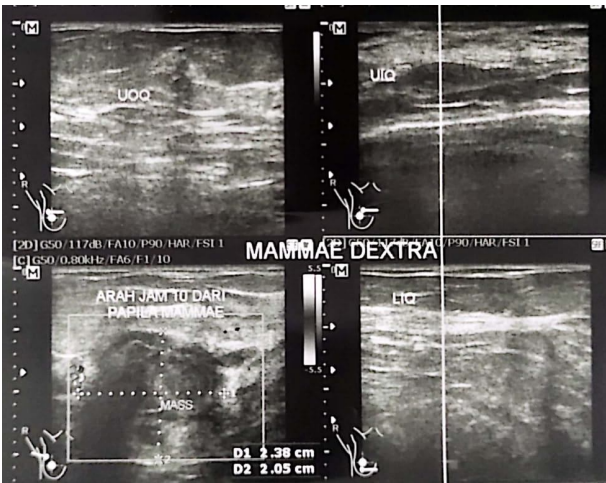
The results of the right breast ultrasound found a highly suspicious malignancy image of the breast – BIRADS 4c
